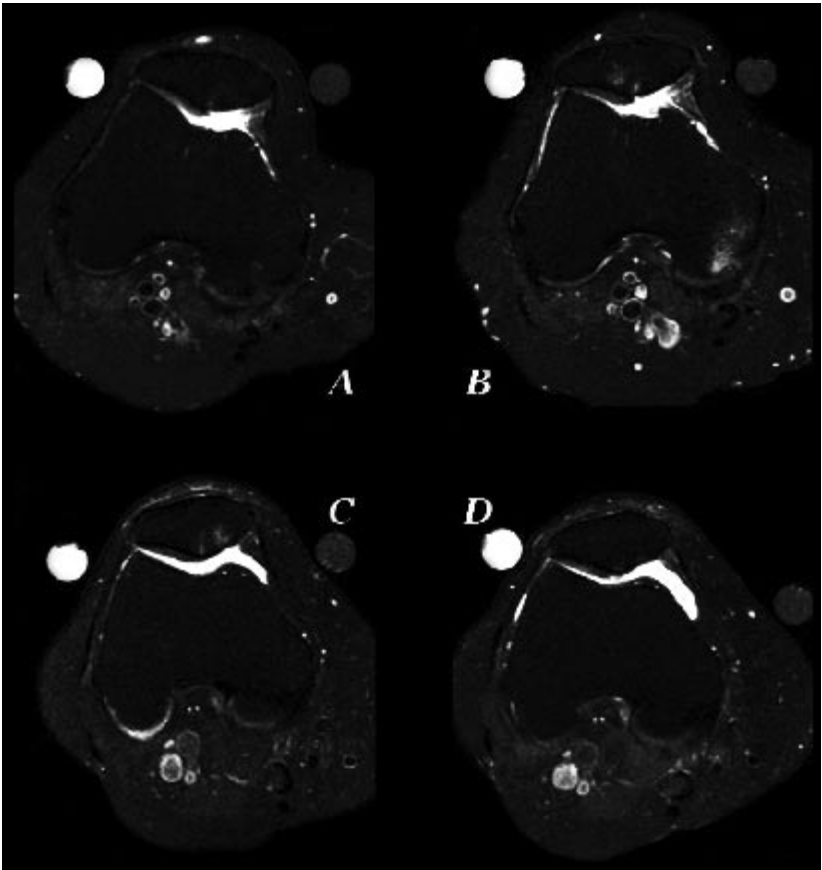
Axial T2-weighted turbo spin echo fat suppressed images. Increase (A= at baseline, B= after two years) in volume of bone marrow edema over 2 years at the crista patella and at the medial femoral condyle. Decrease (C= at baseline, D= after two years) in volume of bone marrow edema over 2 years at the crista and medial part of the patella.
